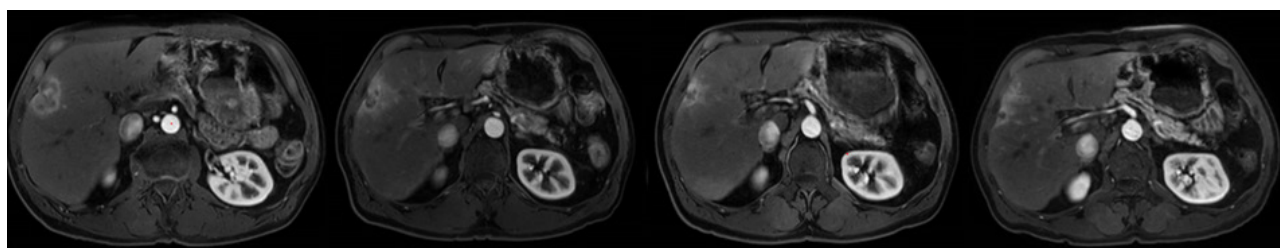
MRI images from a patient who experienced partial response after radioembolization (from left to right: before treatment, at 2 months follow-up, at 4 months follow-up and at 12 months follow-up).
